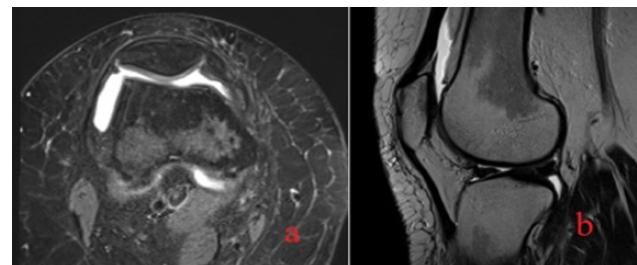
MRI after PRP injection, (a) Axial T2WI and (b) Sagittal STIR revealed improvement of synovitis.
